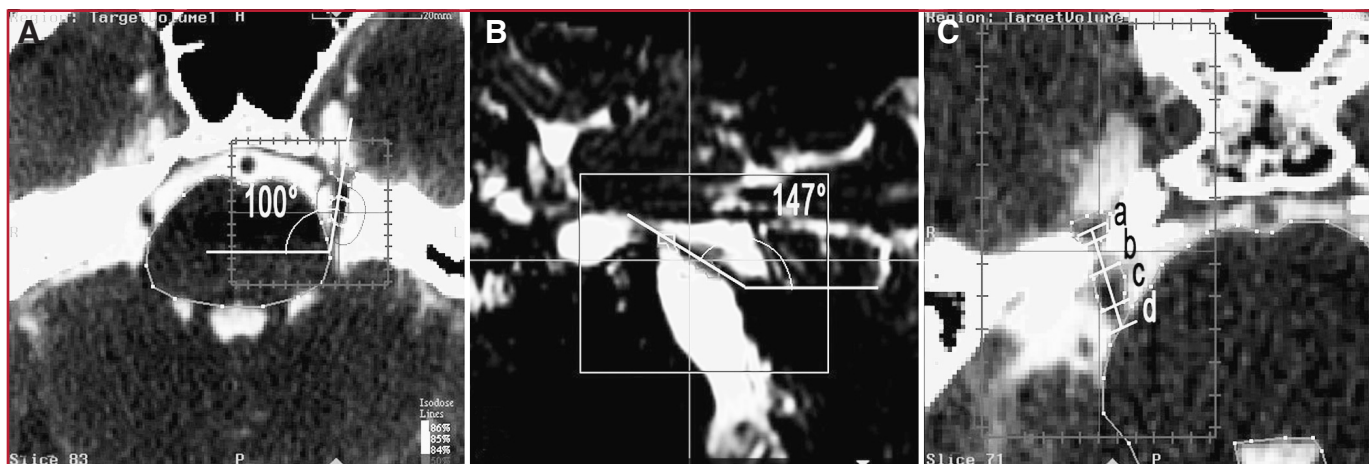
Fused pretreatment magnetic resonance imaging and computed tomographic scans showing measurements of variations of anatomic features related to CyberKnife stereotactic radiosurgery for trigeminal neuralgia. A, the axial angle of the trigeminal nerve is measured from the coronal plane to the axis of the trigeminal nerve. It is 100 degrees in this case. B, the sagittal
